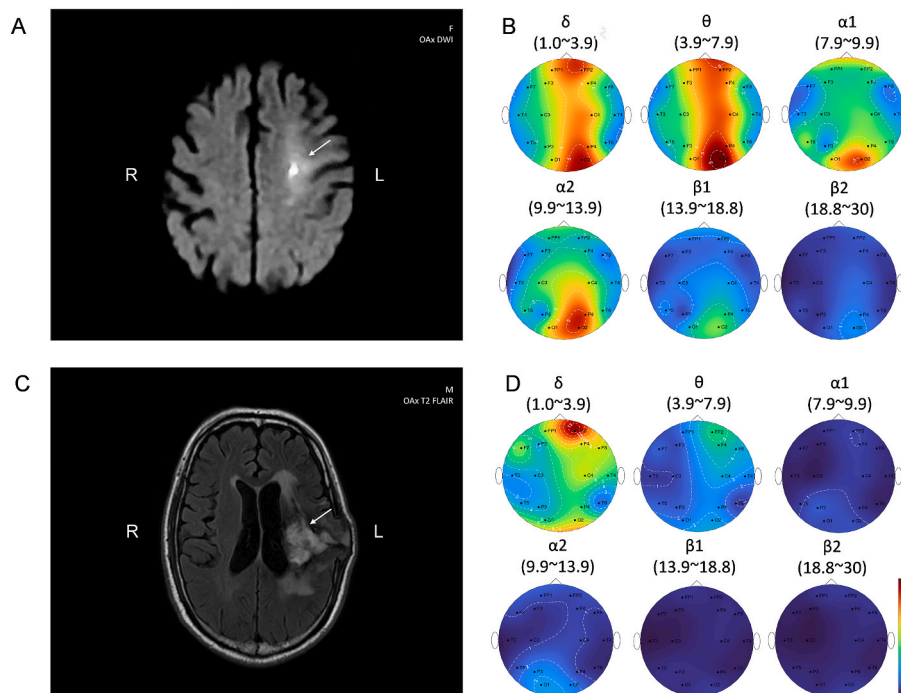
Neuroimaging and continuous scalp EEG monitoring of two cases. (a) Case 1: DWI scanning indicated cerebral infarction in the left frontal lobe and centrum semiovale (white arrow). F, female; OAx, oblique axial view; DWI, diffusion-weighted imaging; (b) Case 1: Six hours of continuous EEG monitoring were recorded during inpatient after seizures. No further seizure began during 6 h EEG monitoring. Most were not associated with epileptiform activity and showed non-specific background slowing (irregular left central theta waves).; (c) Case 2: FLAIR scanning indicated subacute late-stage hemorrhage in the left basal ganglia, lateral ventricle, and centrum semiovale (white arrow). M, male; OAx: oblique axial view; FLAIR, fluid-attenuated inversion recovery; (d) Case 2: Six hours of continuous EEG monitoring were recorded during inpatient after seizures. No further seizure began during 6 h EEG monitoring. Most were not associated with epileptiform activity and showed non-specific background slowing (irregular left central theta waves).
